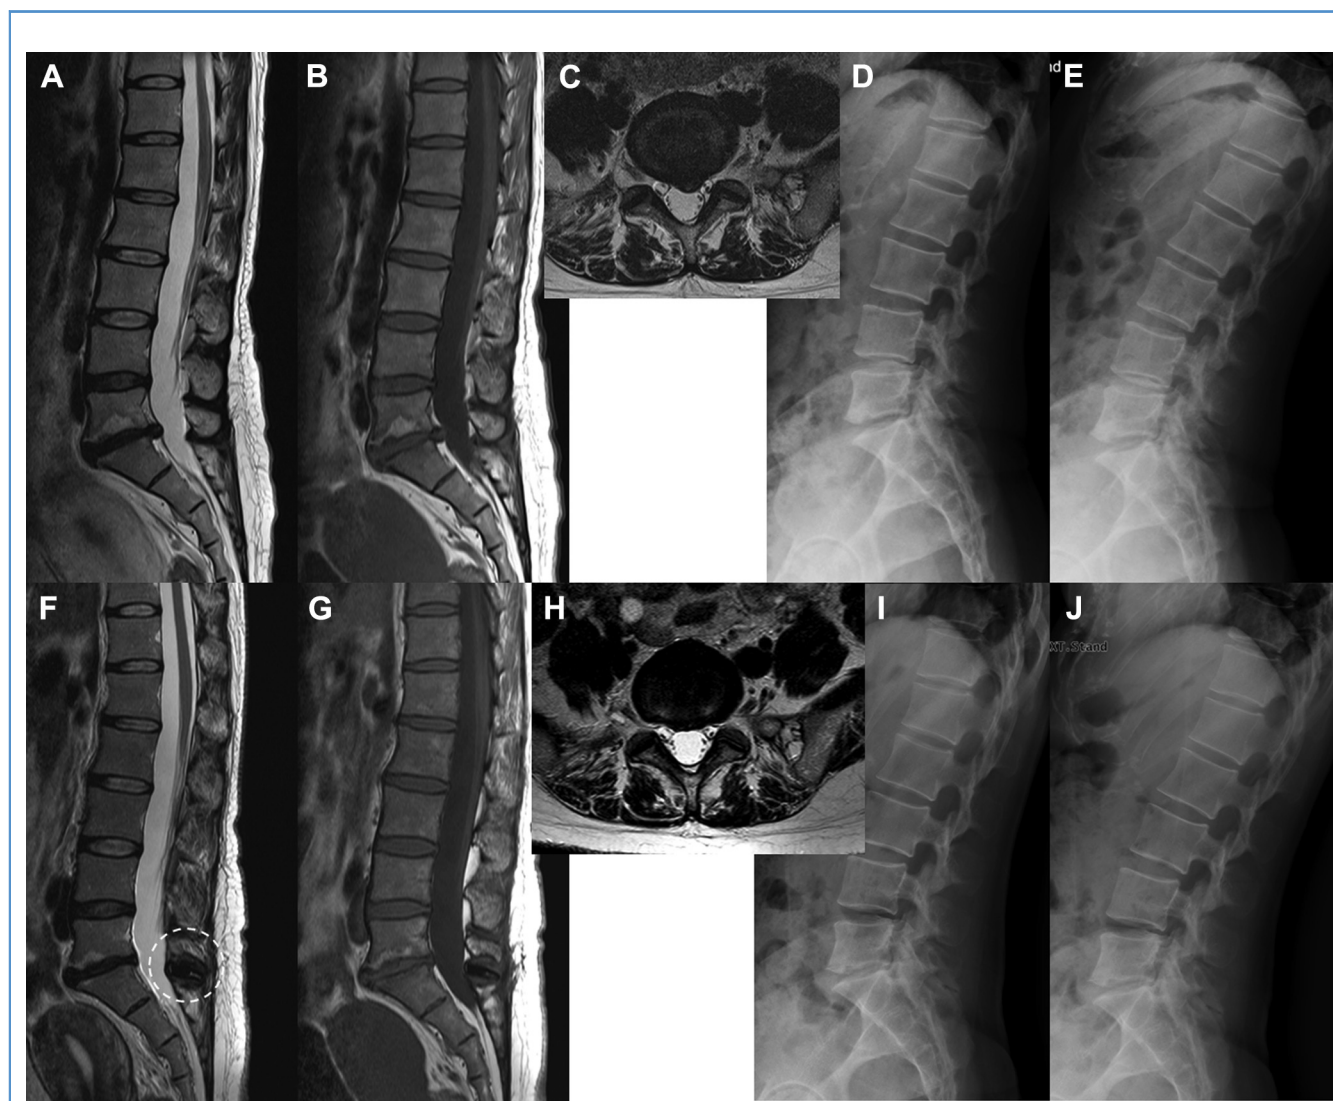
A case presentation of a 37-year-old woman with chronic low back pain for 18 months before surgery. Preoperative magnetic resonance imaging (A–C) and flexion-extension radiography (D, E) showing disc degeneration and central protrusion at the L5-S1 level. Modic change (type 1) at the L5 and S1 vertebra can be seen. At the 24-month postoperative follow-up, magnetic resonance imaging (F–H) and dynamic
